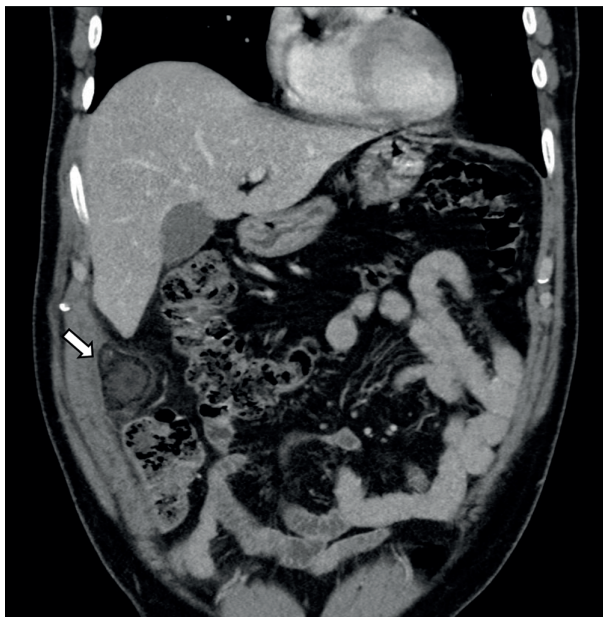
Coronal image of baseline enhanced CT (portal phase) shows a mass of soft tissue attenuation in the right lumbar region surrounded by omental stranding and with a pattern of concentric streaks (white arrow).
